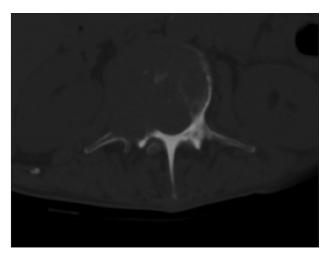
CT axial section showing destruction of vertebral body with involvement of right pedicle, lamina, and transverse process
